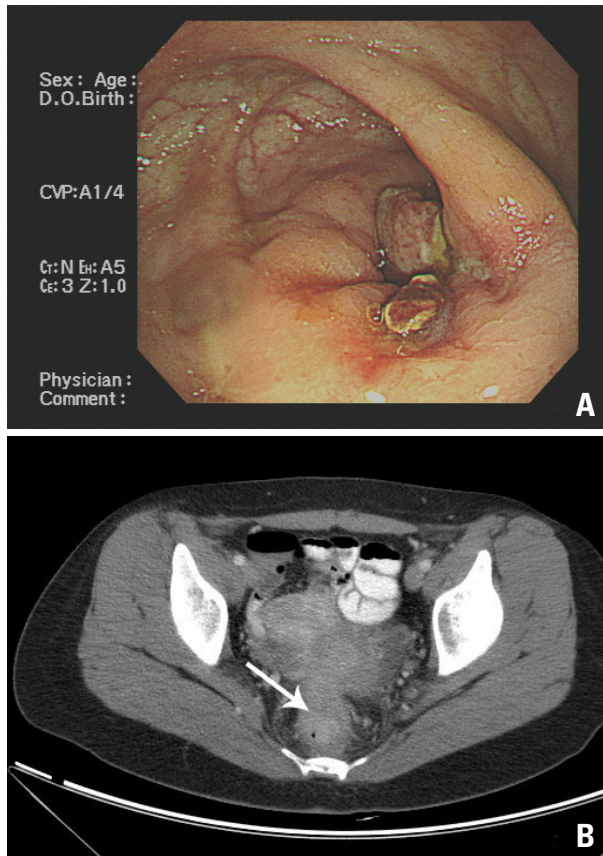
(A) Colonoscopic finding. Ulcerofungating mass 8 cm above the anal verge is suspicious for rectal cancer. (B) CT scan of the pelvis shows rectal mass with perirectal tumor infiltration (Case 2).
